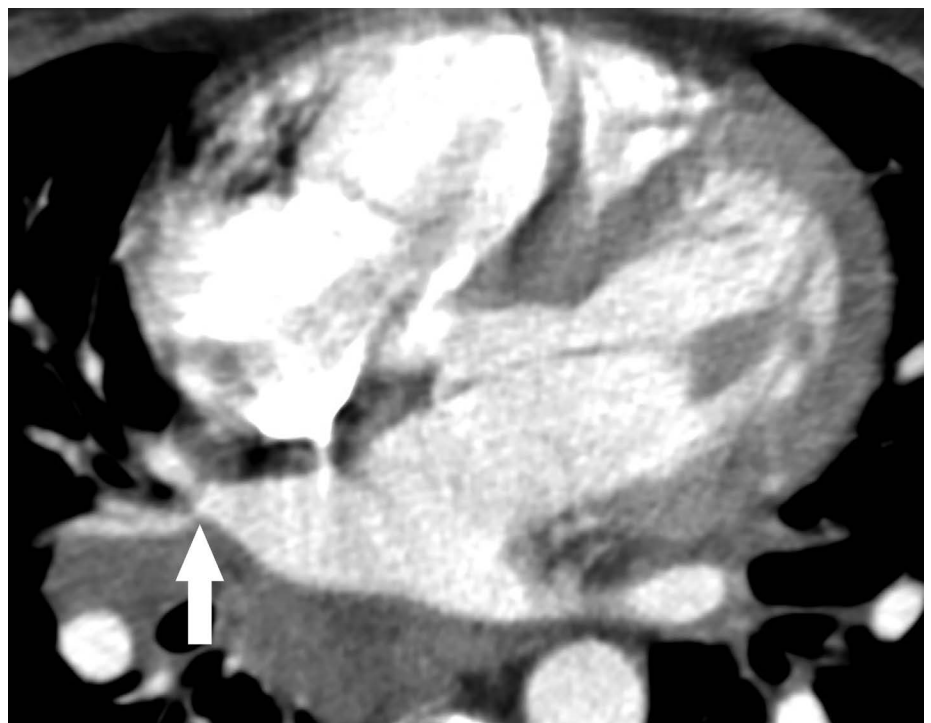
Contrast-enhanced chest computed tomography image shows stenosis at the confluence of the middle lobe pulmonary veins (arrow) and right hilar and subcarinal lymphadenopathy.
